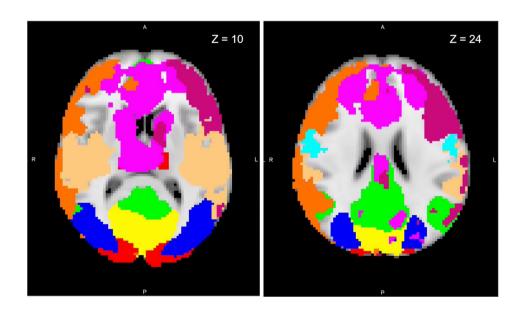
Resting-state functional magnetic resonance imaging network maps identified by Smith and Nichols (2009) overlaid onto a standard brain in Montreal Neurological Institute (MNI) space. Axial slices displayed at coordinate shown. Yellow, medial visual; red, visual occipital pole; blue, lateral visual; green, default mode; not shown, cerebellum; light blue, sensorimotor; light orange, auditory; purple, executive control; orange, right frontoparietal; dark pink, left frontoparietal [Color figure can be viewed at wileyonlinelibrary.com]
